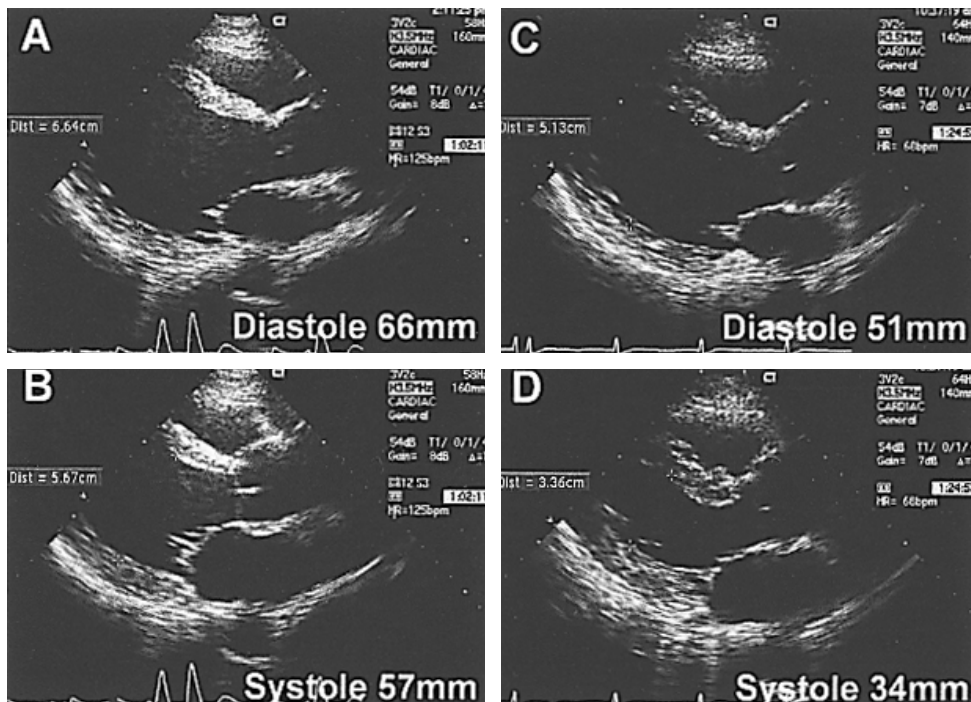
The two dimensional echocardiograms taken before (A, B) and 6 months after the catheter ablation (C, D). There was a markedly dilated left ventricular dimension (LVd), i.e., 66 mm at end-diastole (A), and 57 mm at end-systole (B). The completely normalized LV dimension and contractile function, i.e., an LVd of 51 mm at end-diastole (C), and 34 mm at end-systole (D).
